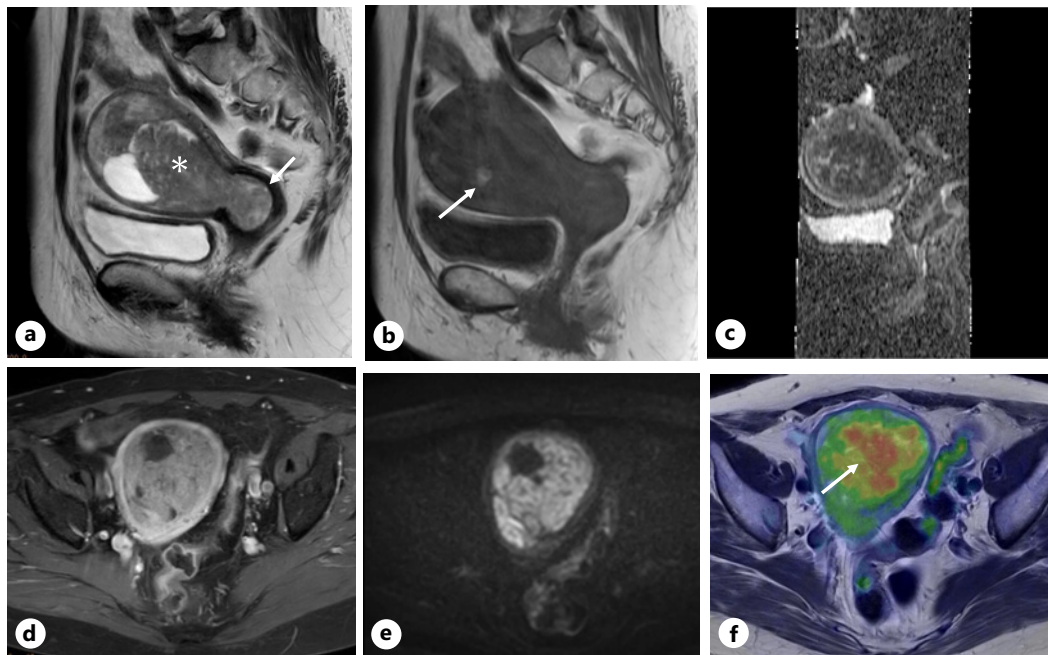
a Sagittal T2-weighted imaging (repetition time [TR]/echo time [TE], 5,857/100 ms) showed a large, heterogeneous, high-intensity mass without myometrial invasion expanding the uterine cavity (*) and extending into the cervical canal (arrow). b The mass showed low signal intensity with areas of slightly high intensity (arrow) on T1-weighted imaging (TR/TE, 625.1/10 ms). c The mass showed low intensity ($0.97 \times 10^{-3} \text{ mm}^2/\text{s}$) on apparent diffusion coefficient maps. d Axial diffusion-weighted imaging. The mass showed inhomogeneous contrast on post-contrast fat-suppressed T1-weighted imaging (TR/TE, 587/10 ms). e The mass showed high intensity on diffusion-weighted imaging ($b = 1,500 \text{ s}/\text{mm}^2$, TR/TE, 7,500/93.4 ms). f Pelvic 18F-FDG positron emission tomography-MRI (PET-MRI) showed increased FDG uptake (maximum standardized uptake value: 6.2) in the uterine tumor (arrow).
